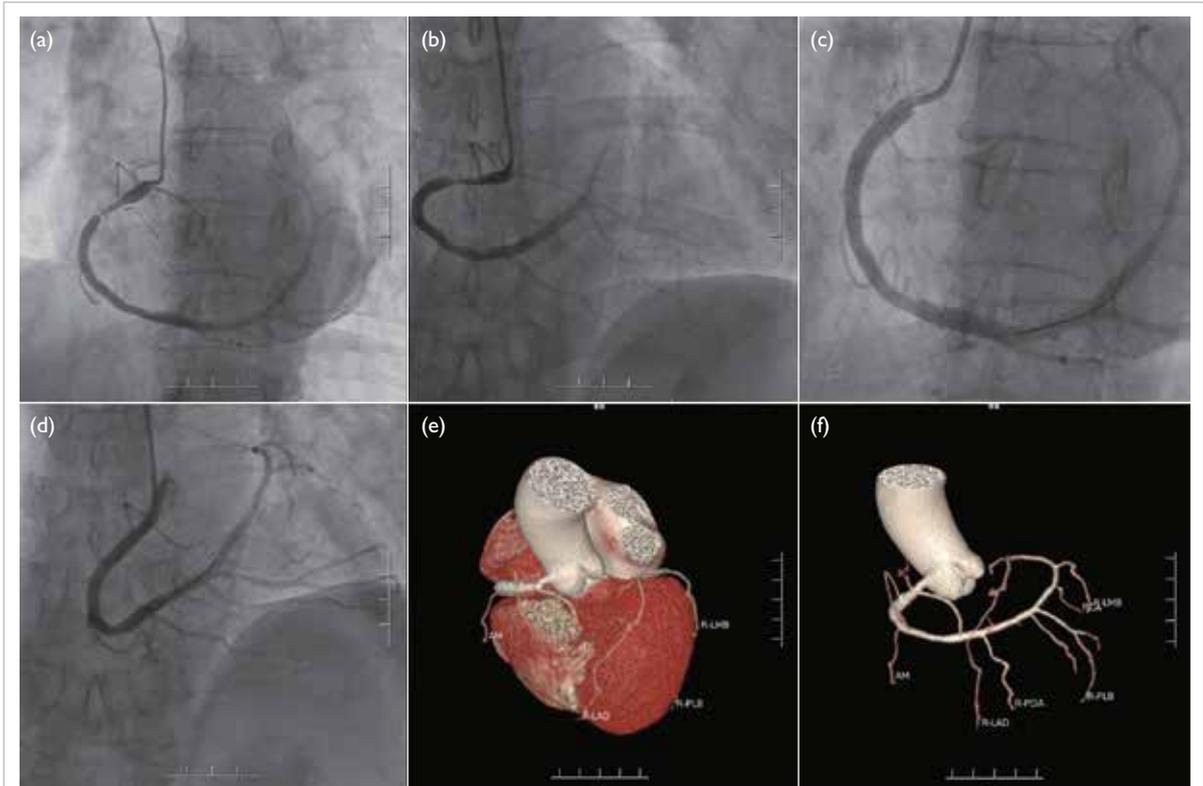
Coronary angiography images of the patient from different projections. Preoperative (a) left anterior oblique view and (b) anteroposterior view of the right coronary artery (RCA). Postoperative (c) left anterior oblique view and (d) anteroposterior view of the RCA. Volume-rendered coronary computed tomography angiography images. (e) Coronary artery tree. (f) Heart and coronary arteries
